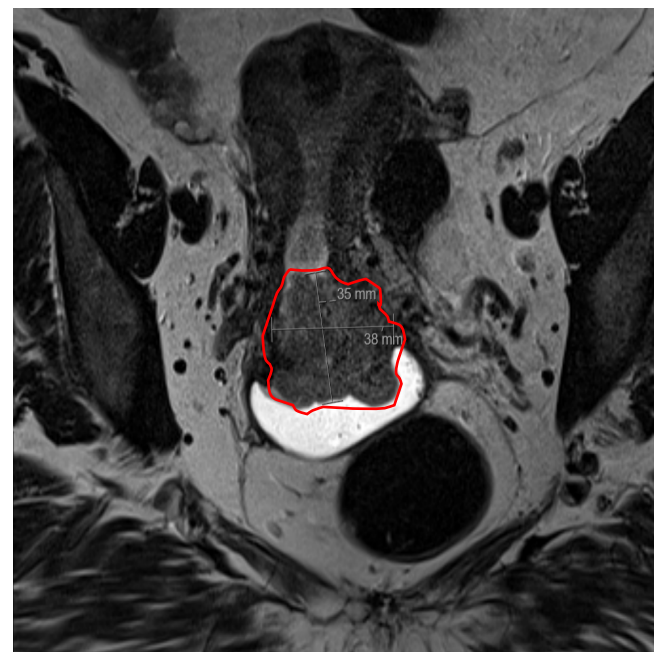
MRI pelvis - exophytic mass arising from cervix
